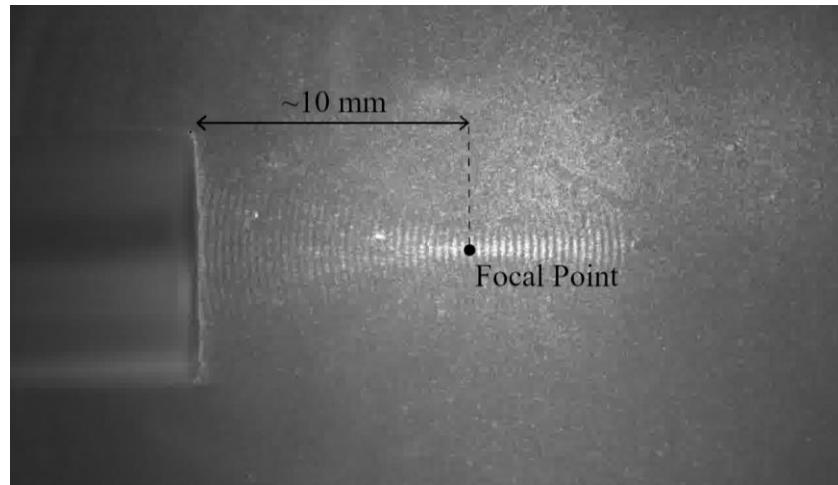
Visualization of 5 MHz ultrasound waves. The image was obtained using Schlieren imaging, which is capable of imaging disturbances in refractory indexes in real time. Ultrasound waves are visible because the pressure gradient influences the refractory index of the medium. Energy is focused at approximately 10mm distance from the transducer.
